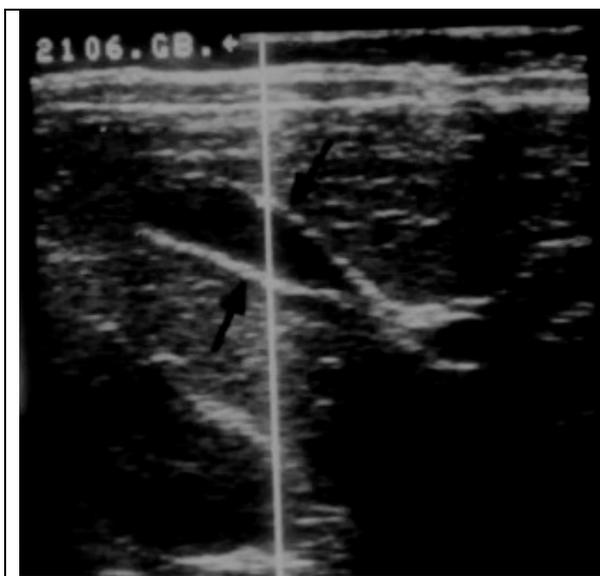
Normal gallbladder ultrasound (arrows).
